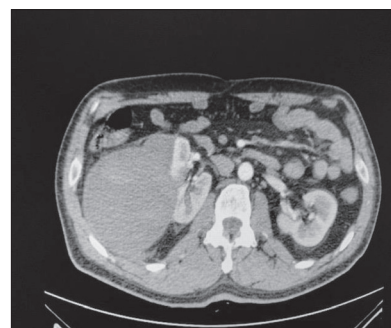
Computed tomography angiogram one month after the acute event
